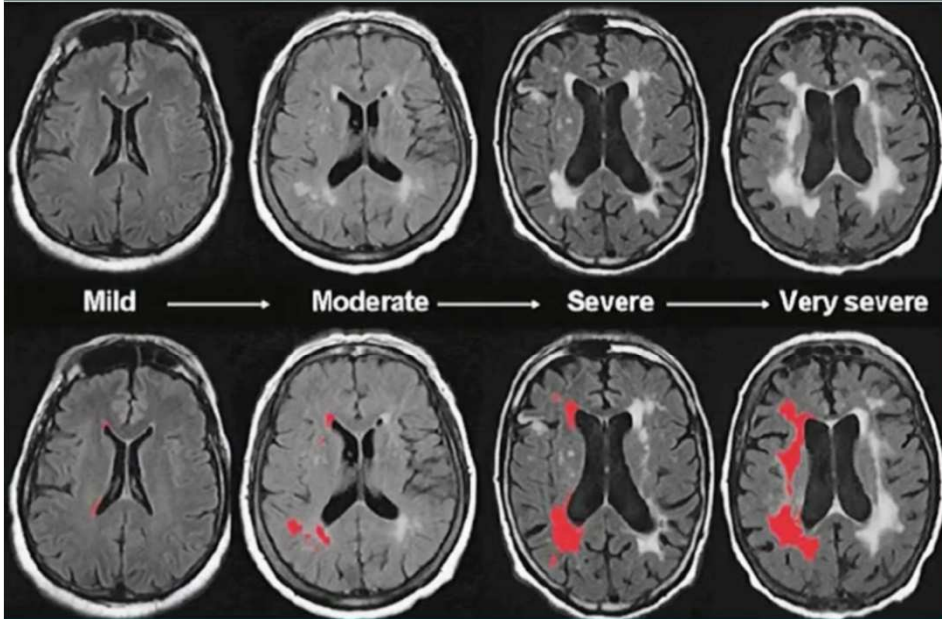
Imagerie morphologique CT/IRM
